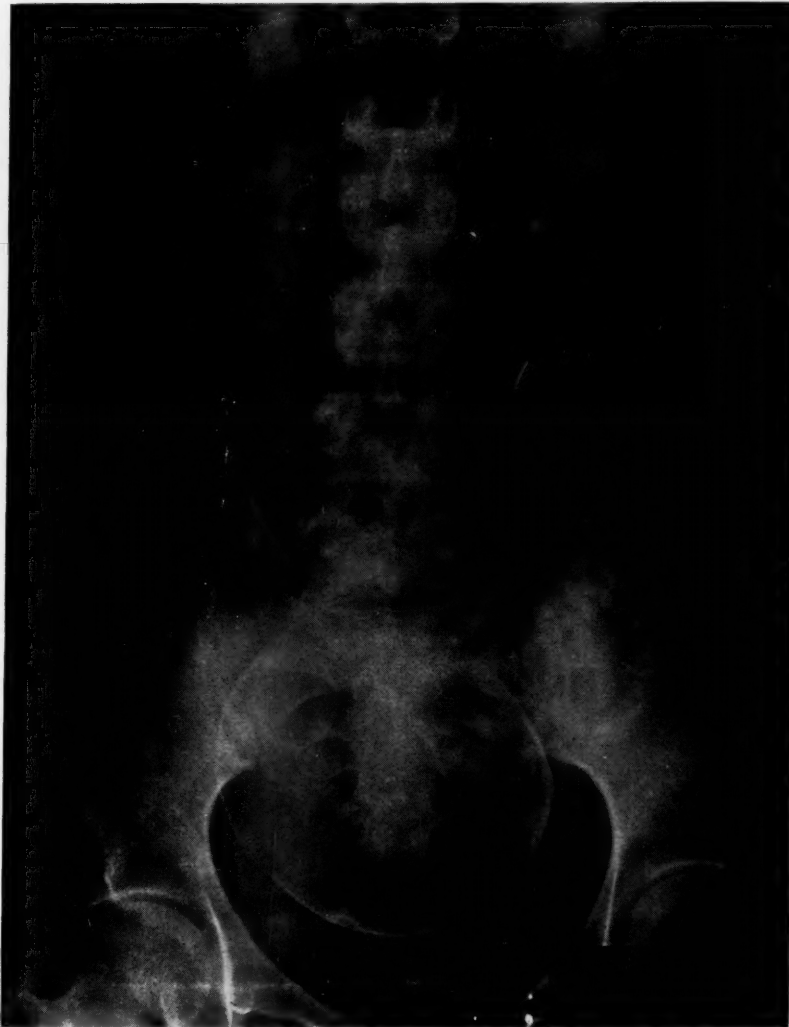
Roentgenogram taken two weeks before term.
